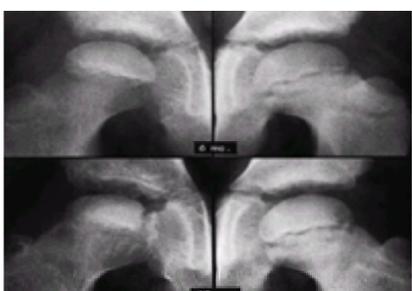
Anteroposterior roentgenogram of a hip in a patient who developed Legg-Calvé-Perthes disease. On the initial film, taken 6 months after symptom onset, the right ossific nucleus is smaller than the left, and the medial joint space is widened. Note also the retained density of the ossific nucleus compared with the normal hip and the relative osteopenia of the viable bone of the proximal femur and pelvis. Ten months after symptom onset, the evolution of the radiographic changes are seen. (From ref. [150](#), with permission.)
